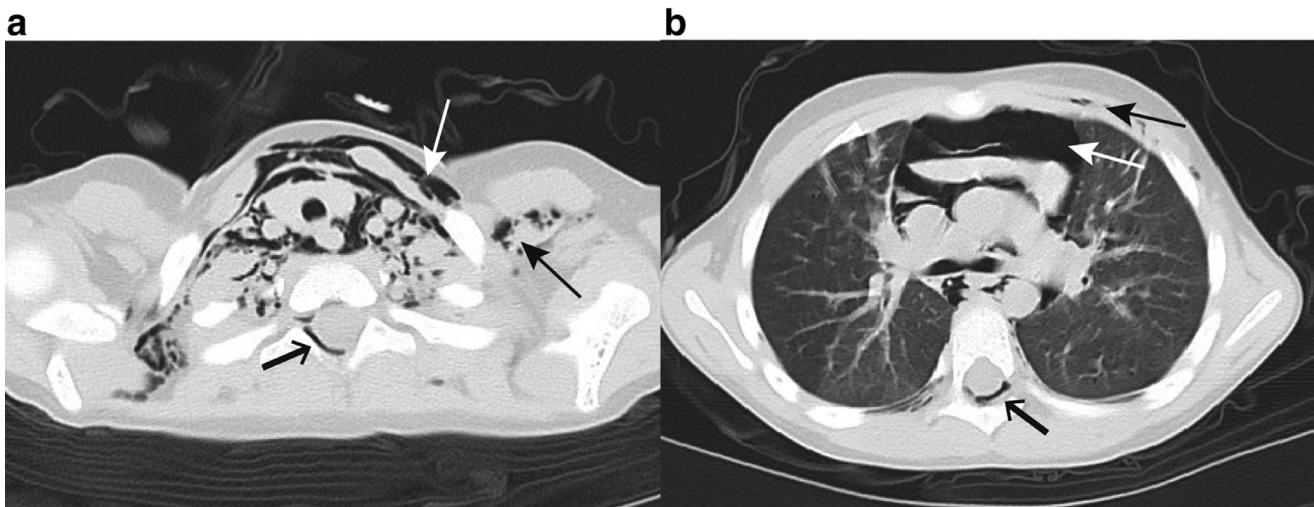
Computed tomography findings at admission of a 4-year-old girl with pneumorrhachis.
